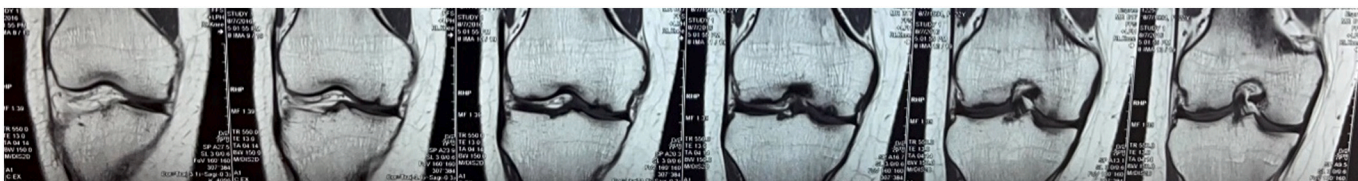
MRI of the right knee preoperative.
